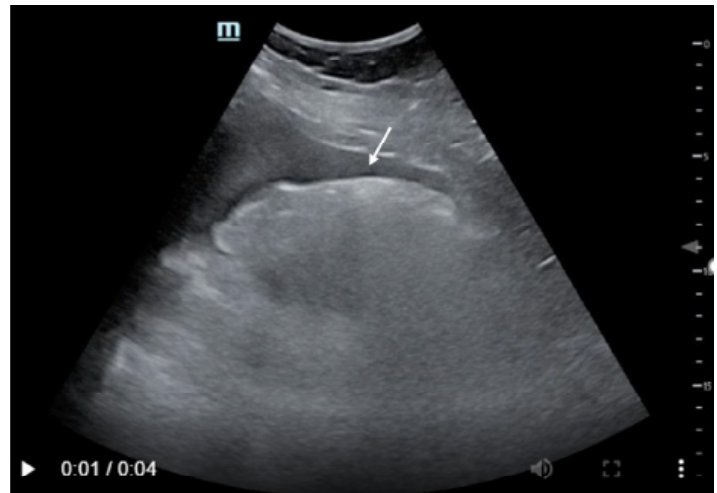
Right upper quadrant view from extended focused assessment with sonography in trauma with white arrow demonstrating free fluid.
